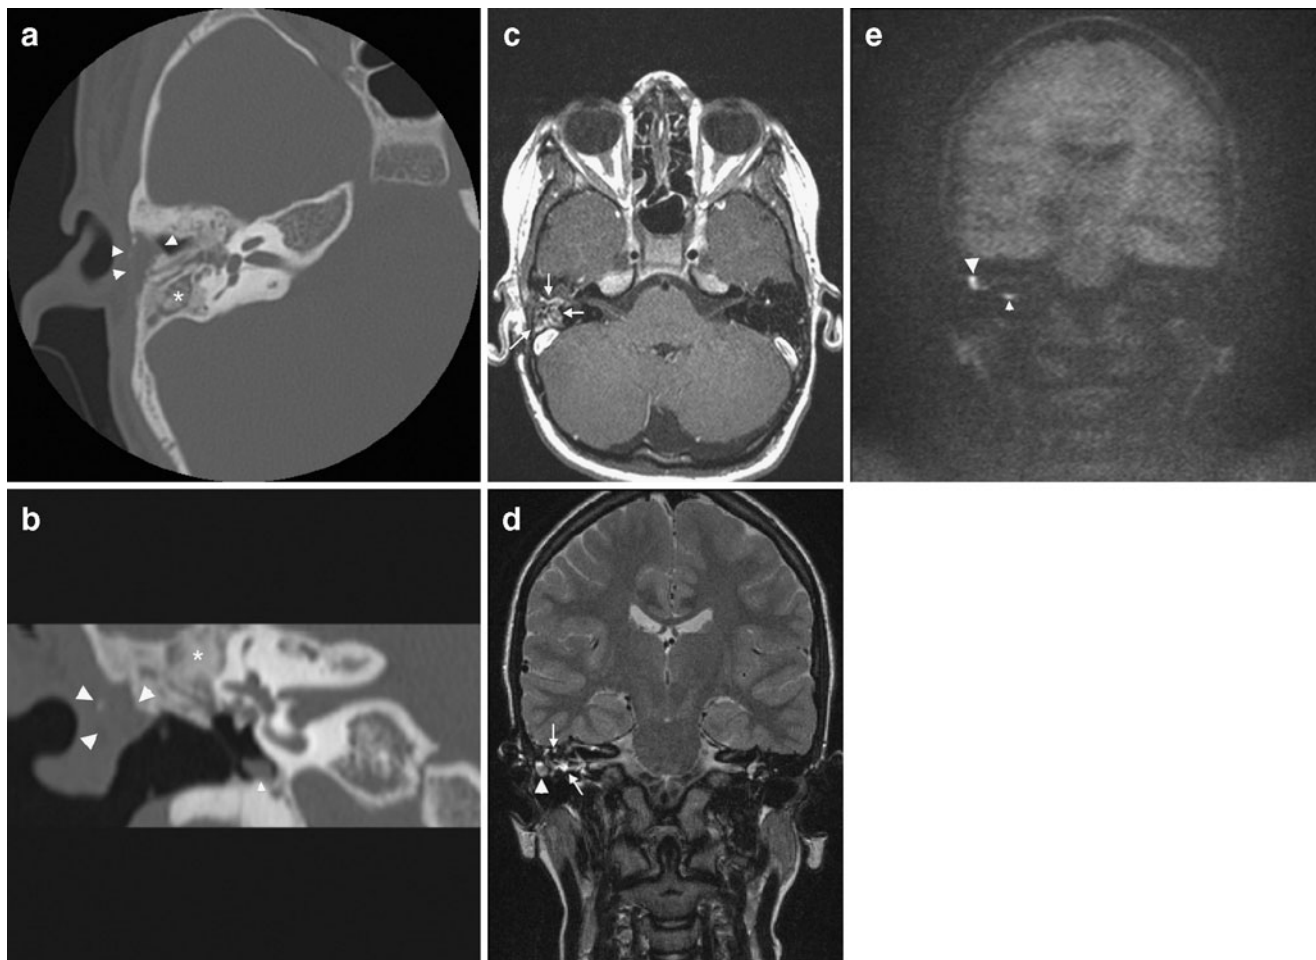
An 18-year-old male operated for a cholesteatoma on the right side using the primary bony obliteration technique (PBOT) or technique of Mercke. In this technique, the cavity created by the canal wall up (CWU) technique is filled up with a mixture of bone and bone pâté. The obliteration of the resection cavity results in a much lower incidence of cholesteatoma recurrence compared to the classical CWU technique. a Axial CT scan at the level of the oval window and vestibule. The CWU tympanoplasty cavity is filled up using material with both soft tissue and bone density (*asterisk*). There are some soft tissues left at its anterior and lateral border (*arrowheads*). b Coronal reformatted CT image at the level of the oval window and internal auditory canal. The CWU tympanoplasty cavity is filled up using a mixture of bone and bone pâté (*asterisk*). Note that there are some soft tissues left in the hypotympanum (*small arrowheads*) and lateral and caudal to the cavity (*large arrowheads*). c Axial delayed post-gadolinium T1-weighted image at the level of the vestibule and internal auditory canal (same level as a). The signal intensities of the PBOT are mixed and inhomogeneous (*arrows*). Due to the mixed character of these signal intensities, it is impossible to detect the characteristic signal intensities of a residual cholesteatoma. No
